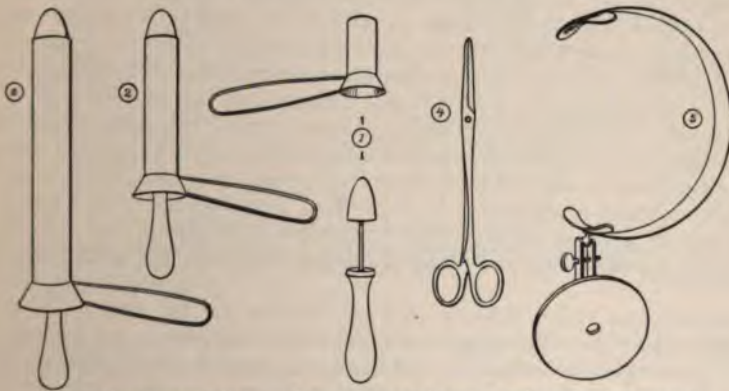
INSTRUMENTS USED IN EXAMINING THE RECTUM BY INDIRECT INSPECTION.
